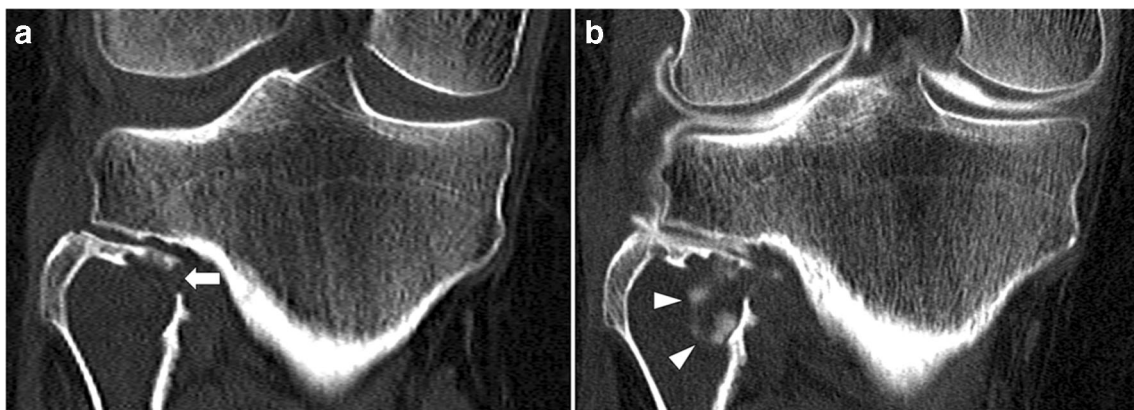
a Coronal CT reformat of the knee obtained before knee arthrography demonstrates the lack of increased X-ray attenuation in the fibular lesion as well as a cortical defect (arrow). b Coronal CT reformat after knee arthrography demonstrates increased attenuation within the fibular lesion (arrowheads) due to contrast material pouring
